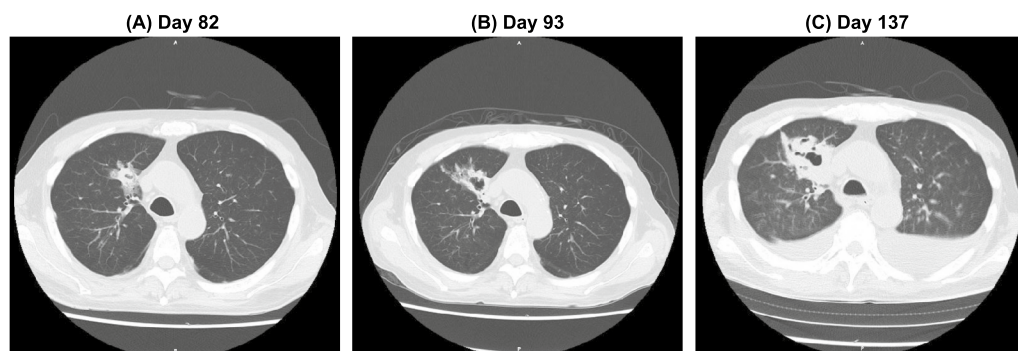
The time course of lung CT images. The time course of lung CT images is shown. A Day 82 when the infiltration shadow is observed at the right upper lobe. B Day 93 when the cavity formation was observed. C Fixed cavity on day 137
